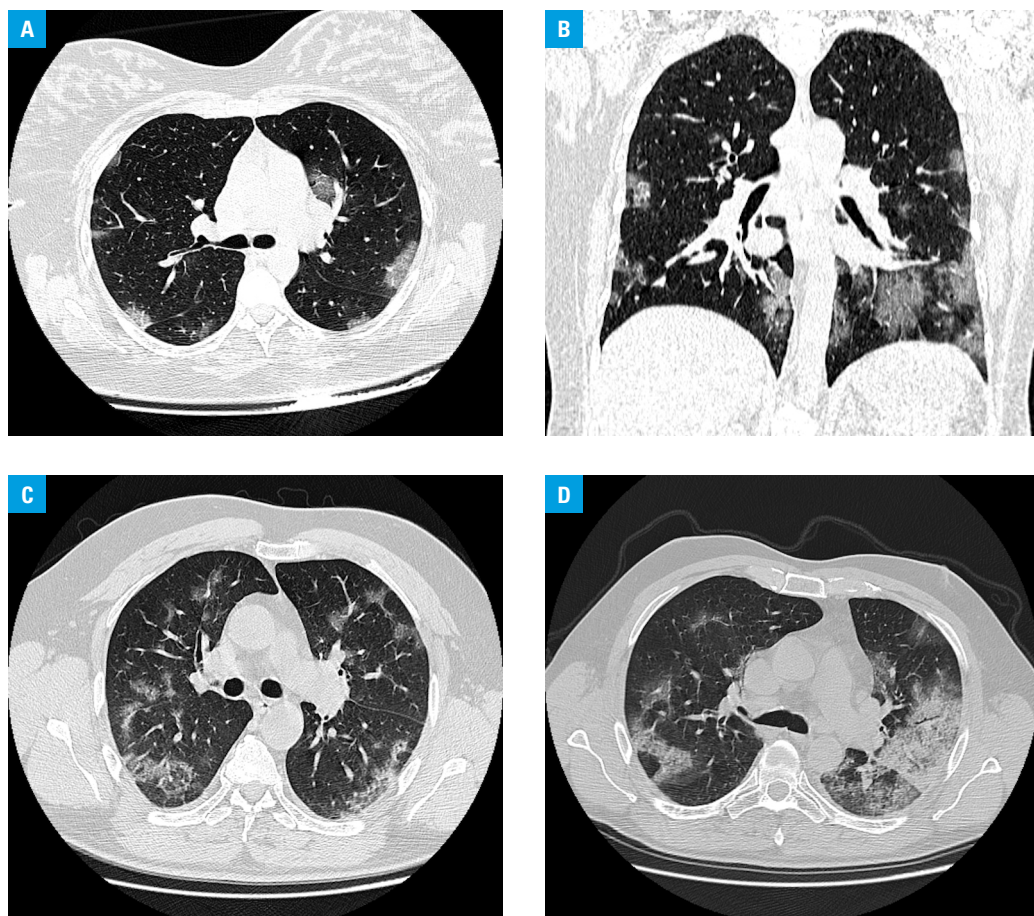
Typical chest computed tomography (CT) images in coronavirus disease 2019: A, B – noncontrast axial and coronal plane chest CT images of a 20-year-old man with mild COVID-19 pneumonia. CT scans show ground-glass opacities in multiple lung segments. C – a 49-year-old man with COVID-19 presenting with fever lasting for 8 days. CT scan in the axial plane shows consolidation in the left lobe subpleural area and bilateral ground-glass opacities. D – a 66-year-old man with COVID-19 presenting with cough and myalgia lasting for 7 days. CT scan shows a reticular pattern superimposed on the background of ground-glass opacities (crazy paving appearance).
